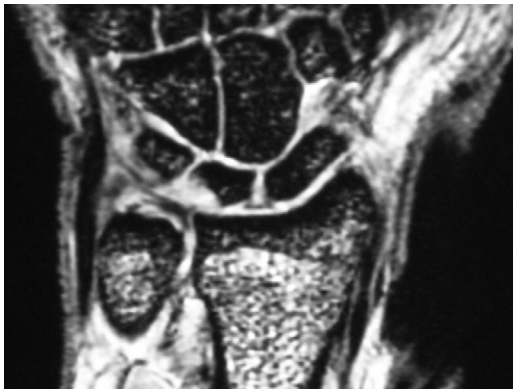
Magnetic resonance image with findings of disruption of the TFCC and subchondral edema in the proximal ulnar border of the lunate in ulnar impaction syndrome.
